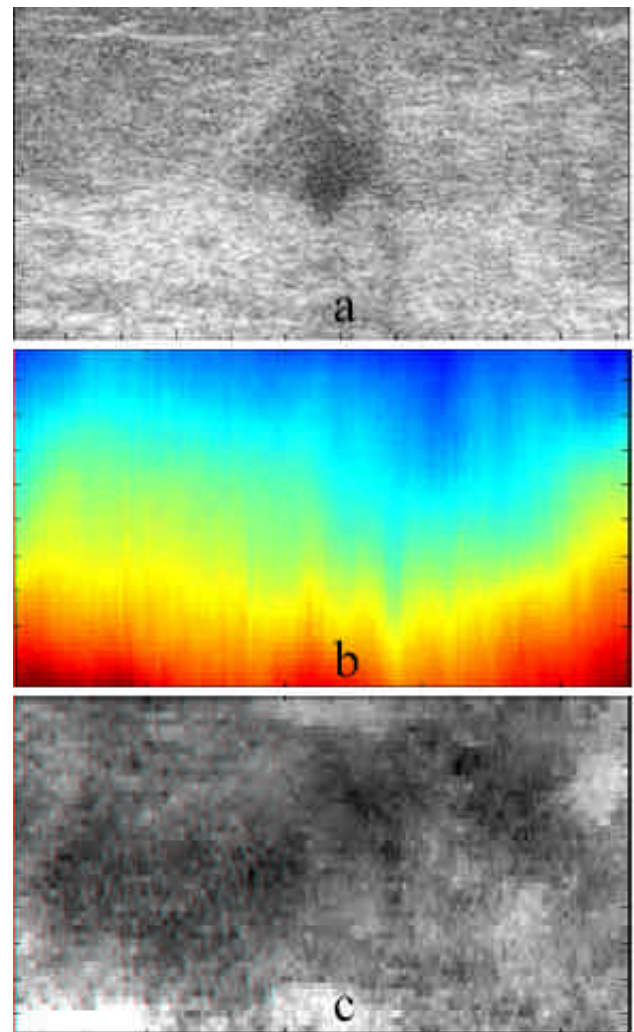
Sonogram (a), displacement map (b) and elastogram (c) of a 10 mm IDC (83 years old patient). Neither the elastogram (Fig. 5c) nor the displacement map exhibit any particular contrast around the lesion area.
